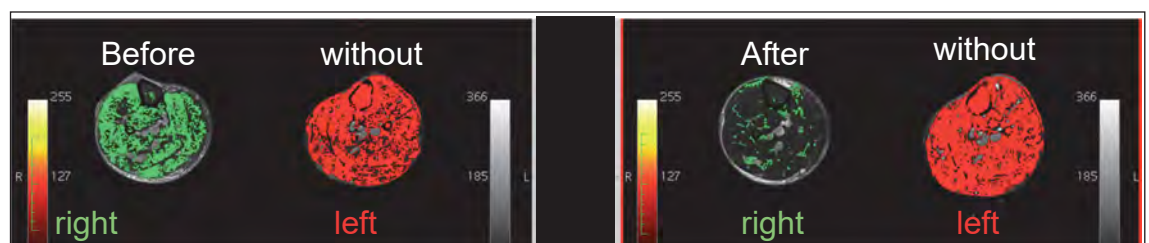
T2-weighted MRI image of the lower leg of patient S before and after treatment of only the right leg, water content on the right coloured green, left red. The water content is markedly reduced in the right leg, but is unchanged on the left, untreated leg.
